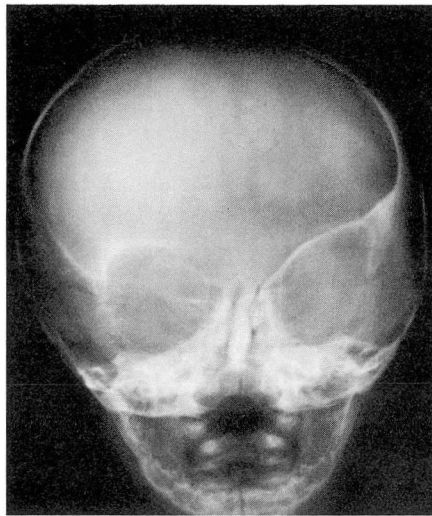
Case 3. Preoperative roentgenogram showing the teardrop left orbit and notably slanted nasal septum.
